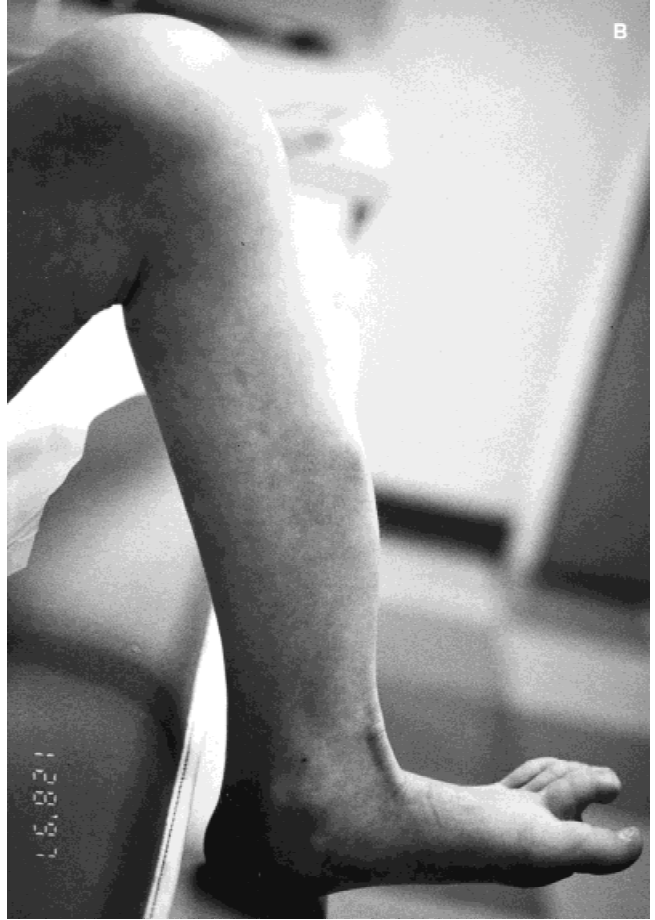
Six-year-old girl with left tibial bowing. A: Anterior view. B: Lateral view. C: X-ray.
